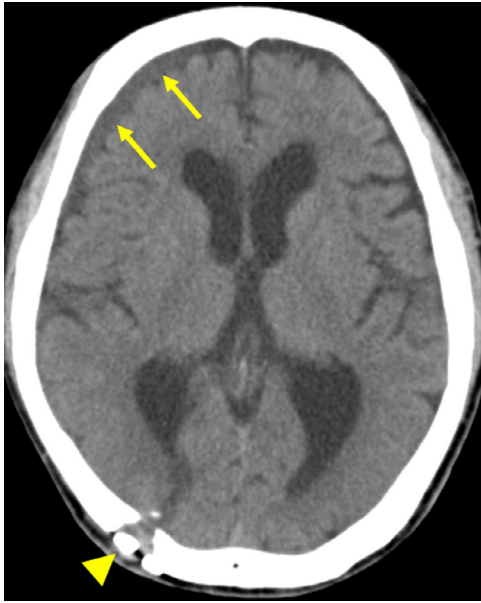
Noncontrast axial computed tomography scan on the 40th postoperative day demonstrates complete resolution of intracerebral and intraventricular hemorrhages. In addition, thin subdural fluid accumulation is evident in the right frontal convexity (arrows). Arrowhead: burr-hole.
